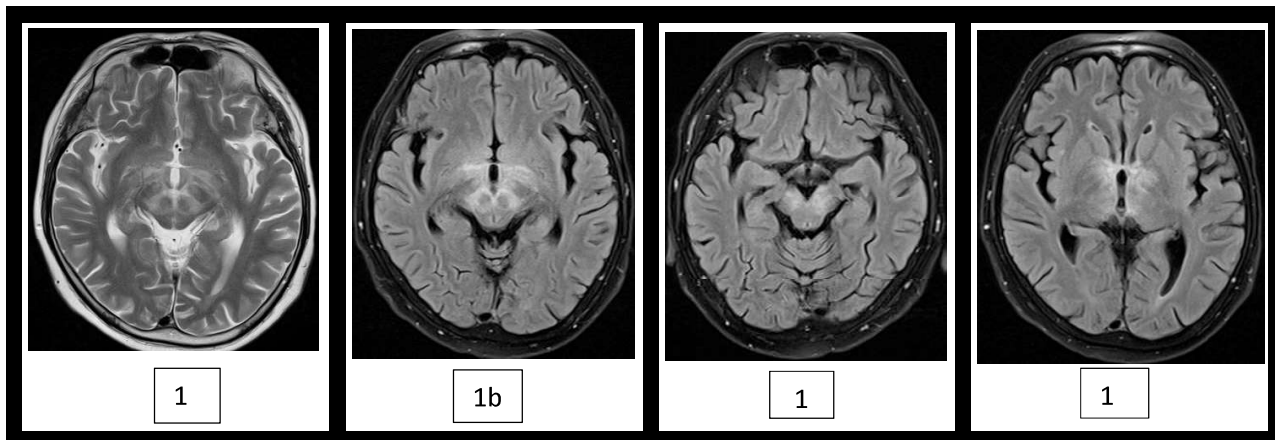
Axial T2WI shows hyperintense signals of the midbrain and hypothalamus (1a) which are not suppressed on FLAIR (1b,1c). There are also hyperintensities of the 3rd ventricle periventricular regions with mild involvement of the globus pallidus, thalamus and internal capsule (1d).
